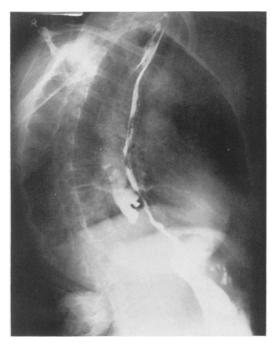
Roentgenogram demonstrating a posterior perforation of the cervical esophagus in a 73-year-old woman with moderate kyphosis and spurring of the vertebrae and following a diagnostic esophagoscopic examination.
